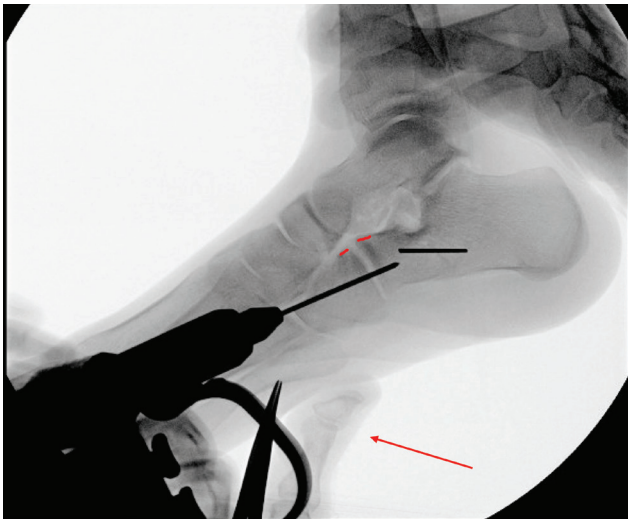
Lateral C-arm radiograph of the foot in a 17-year-old male undergoing lateral column lengthening. Note thumb pressure (red arrow) pushing up on the plantar aspect of the cuboid as the pin is advanced across the CC joint, preserving a normal relationship of the joint (red lines).
